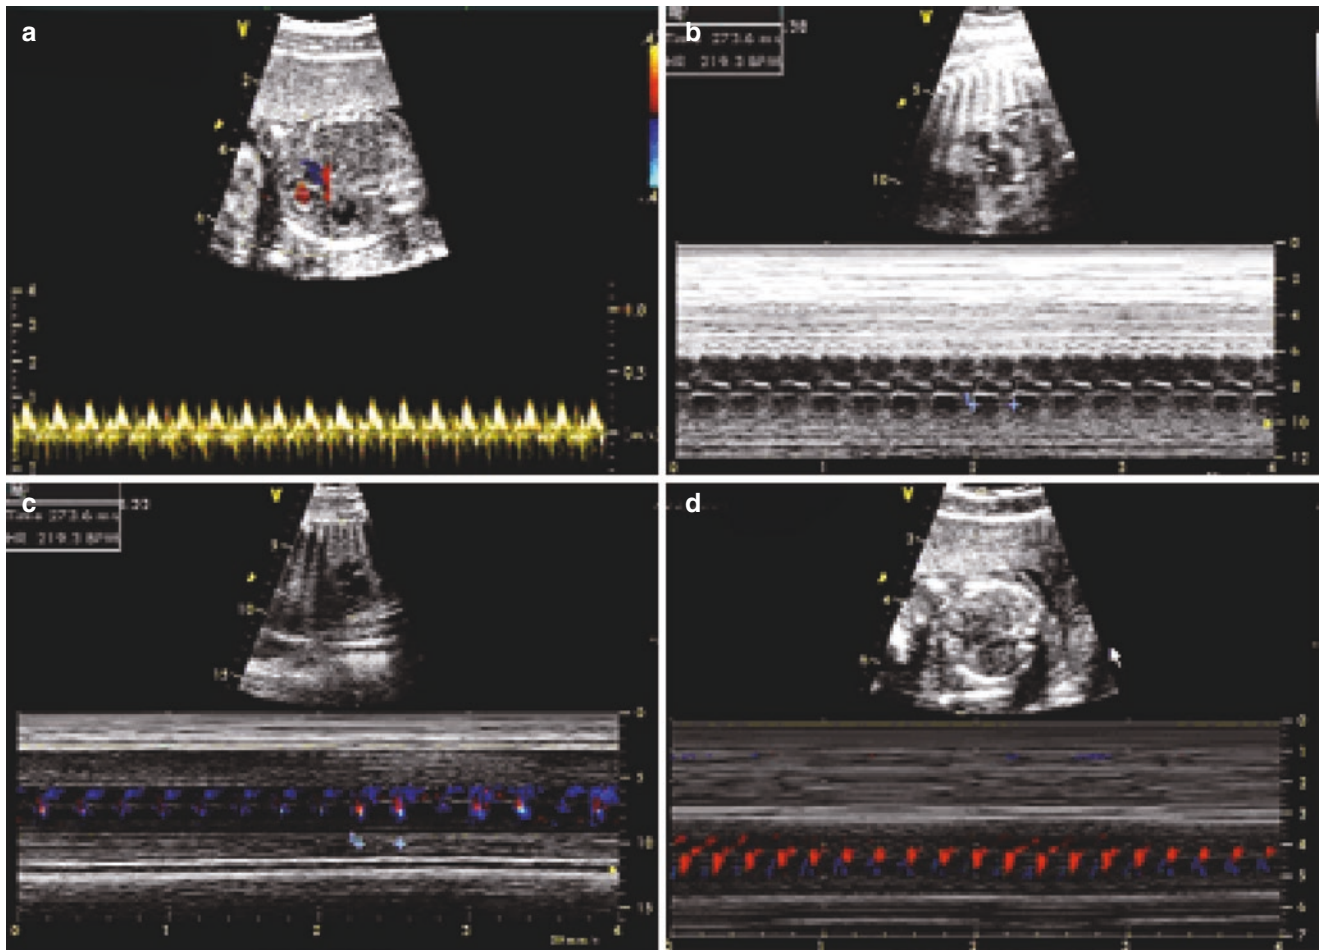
Supraventricular tachycardia. (a) Doppler of supraventricular tachycardia. (b) M-mode ultrasound of fetal supraventricular tachycardia. (c, d) M-mode color ultrasound in fetal supraventricular tachycardia
